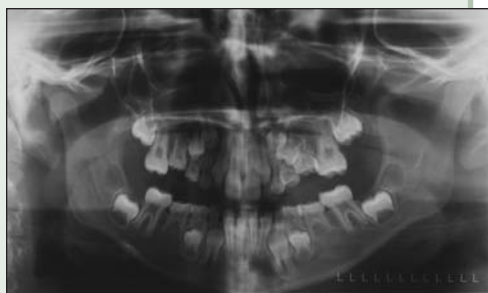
Panoramic radiograph displays mesial tipping of maxillary and mandibular first permanent molars due to submergence of the maxillary and mandibular second primary molars.
